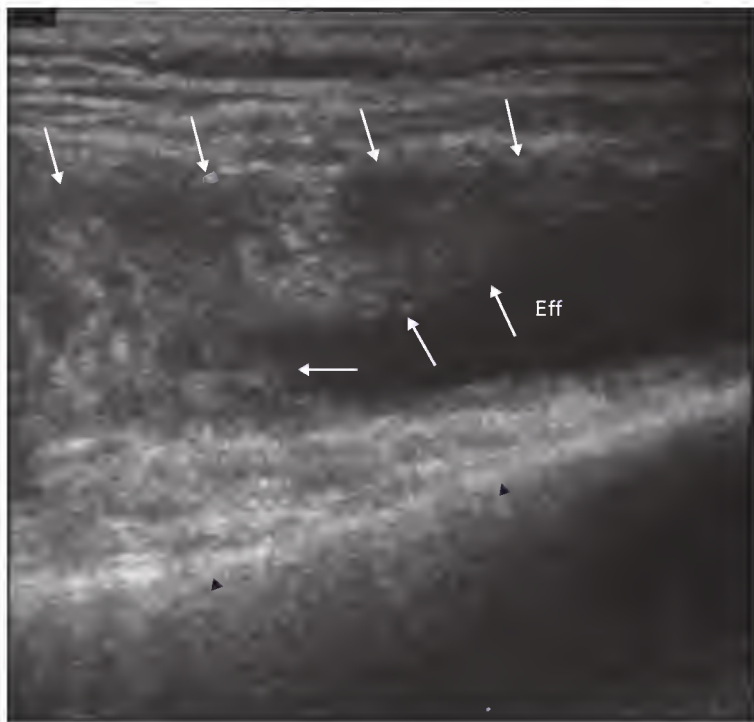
Sonogram of the knee joint (taken longitudinally through the suprapatellar pouch). The anterior cortex of the femur is shown (black arrowheads). A knee joint effusion (Eff) and synovitis are apparent in the suprapatellar pouch (white arrows).
